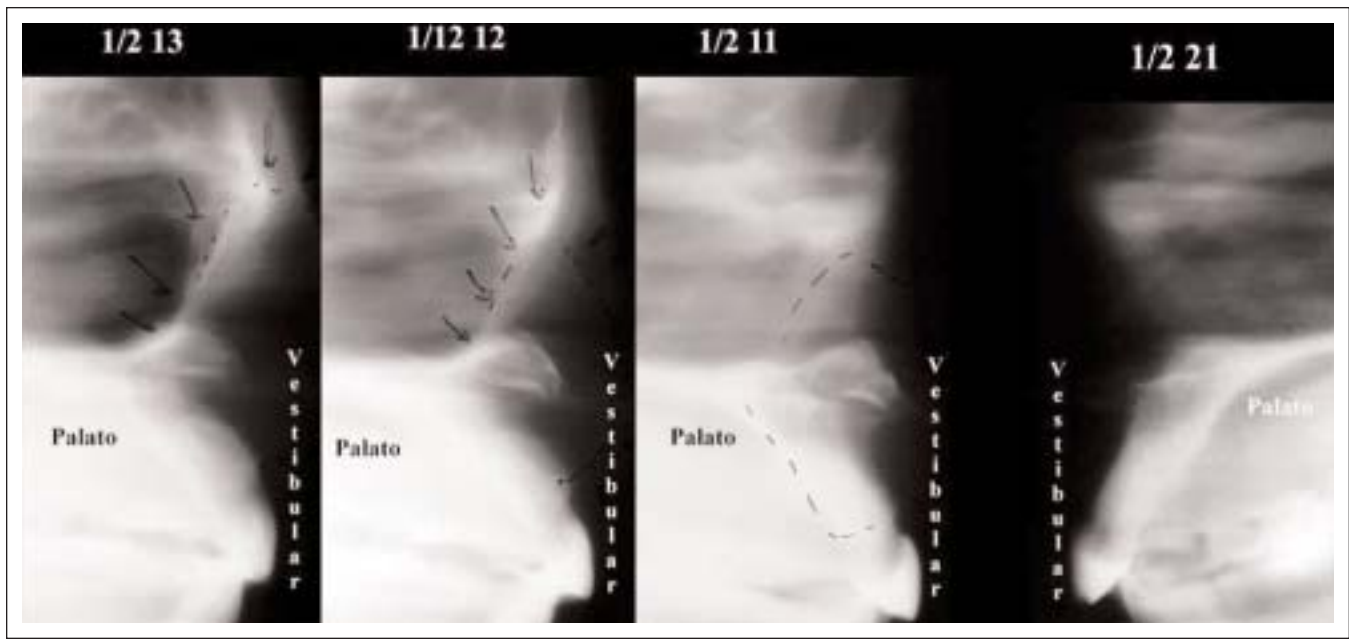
Linear tomography exams, cross sectional tomograms, were performed at the anterior region. It was possible to visualize the radiographic appearance of a displaced tooth under the nasal floor associated with the expansive osteolytic lesion.
